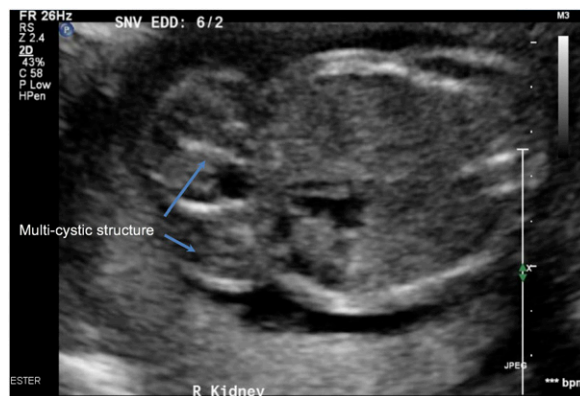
Ultrasound scan at 22 weeks' gestation showing right-sided multicystic dysplastic kidney.
